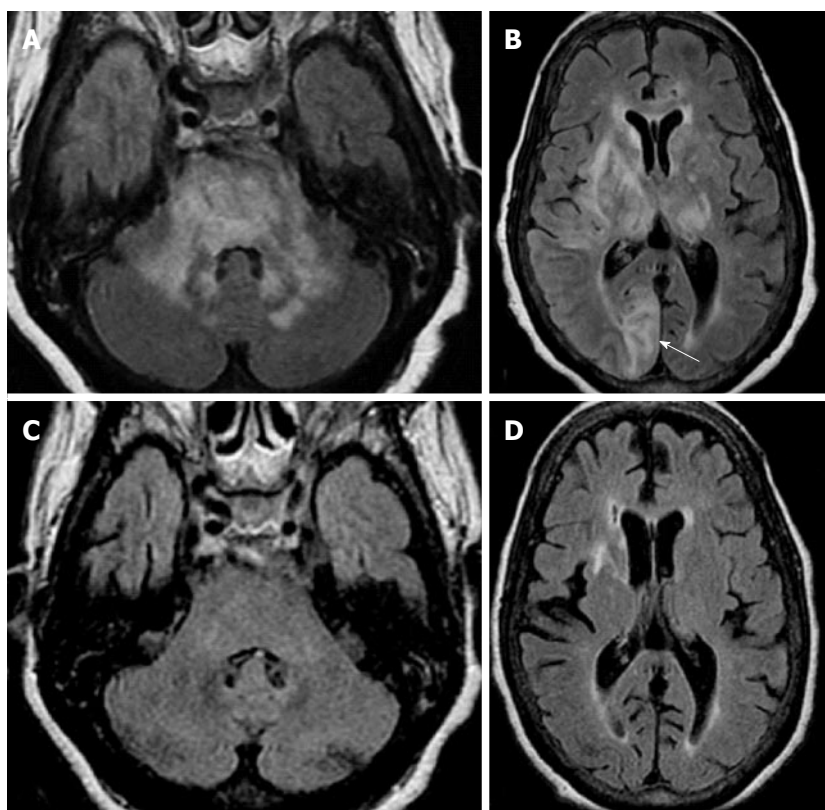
Posterior reversible encephalopathy. A and B: Axial FLAIR images in an hypertense encephalopathic patient show symmetric bilateral areas of abnormal signal in the MCP and pons. Concomitant involvement of supratentorial subcortical white matter in a “vasogenic type pattern” as well as cortical involvement (arrow on B) was noted; C and D: Three months f/u after control of hypertensive crisis show almost complete resolution of abnormal signal in MCP, pons and supratentorial regions to include the basal ganglia/thalami. Given the asymmetric distribution of supratentorial lesions, PML could be included in the differential. However, cortical involvement is not characteristic for PML. This case could be considered “atypical PRES” and proved by resolution of abnormal white matter disease (compare with Figure 3 where no resolution is noted). PRES: Posterior reversible encephalopathy; MCP: Middle cerebellar peduncles; PML: Progressive multifocal leucoencephalopathy.
